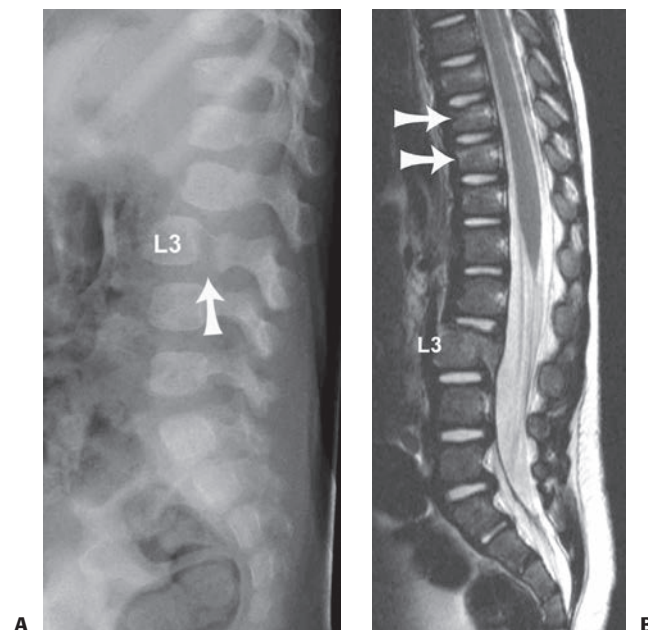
Lumbar spine fracture in a 16-month-old male victim of nonaccidental trauma. A: Lateral lumbar radiograph shows lucency through the L3 synchondrosis (*arrow*) with anterolisthesis of L3 body on L4. B: Sagittal T2-weighted MRI reveals hyperintense signal within the bone marrow of the fractured L3. Slight compression fractures of T10 and T11 are also noted (*arrows*).
